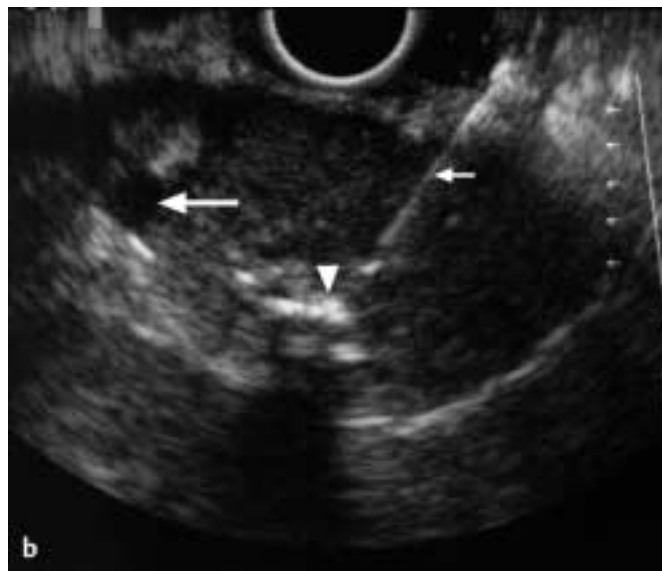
Computed tomogram, showing a partially calcified mass in the area of the pancreatic tail. b Endoscopic ultrasonography using a linear-array echo endoscope reveals a solid hypoechoic tumor with cystic areas (large arrow) and calcifications (arrowhead). Fine-needle aspiration is being carried out (the small arrow indicates the 22-gauge needle).
